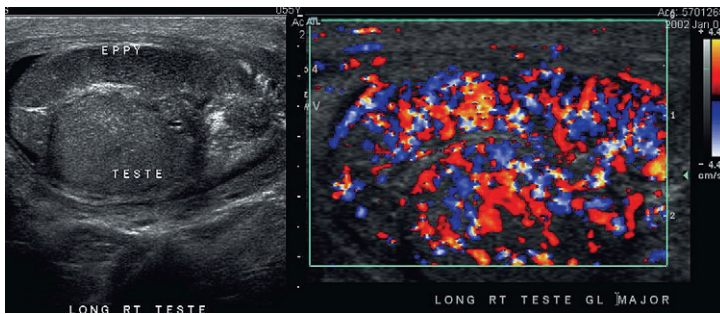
Longitudinal grey-scale and colour Doppler image of the right testicle. The patient presented with severe pain. Both the testis and epididymis are oedematous, swollen and hypoechoic. Colour Doppler shows exuberant flow through both structures. The diagnosis is epididymo-orchitis.
